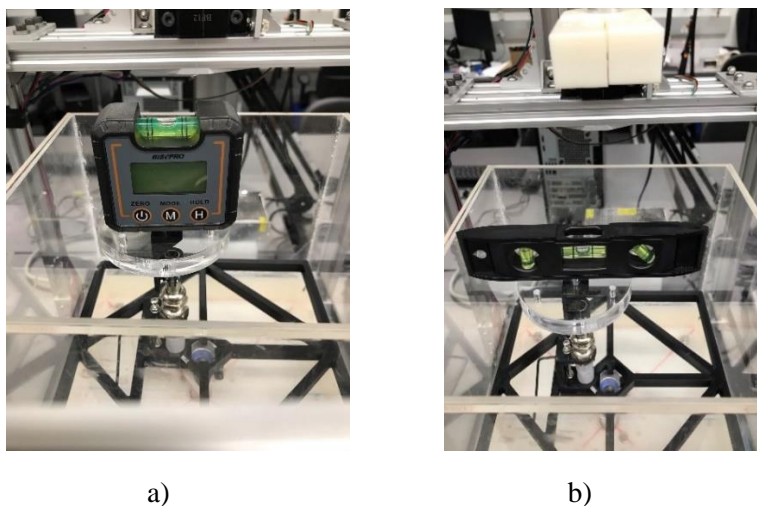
The water container and the ultrasound transducer leveling.
